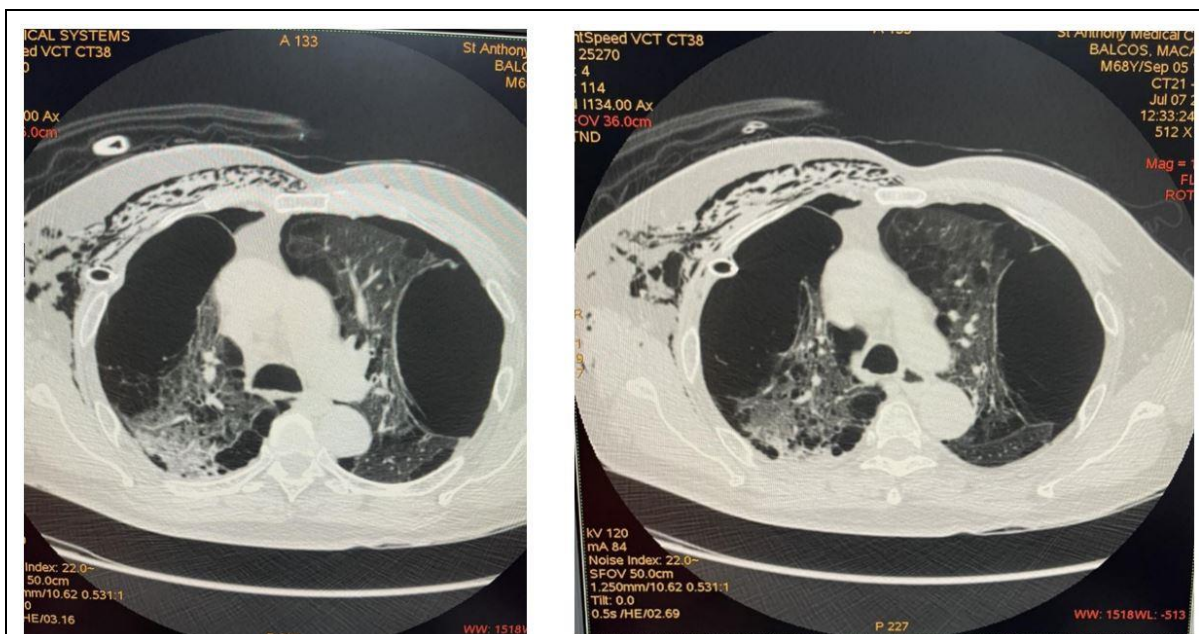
HRCT; Multiple bullae and bleb formations, both upper hemithoraces. Centrilobular and paraseptal emphysematous changes, bilateral. Minimal pneumothorax, bilateral, more pronounced on the left. Extensive subcutaneous emphysema, both anterior and right lateral chest walls as well as in the right axillary, right upper arm and right lower cervical regions. Reticular and ground-glass opacities in the right lung are likely due to an infectious/inflammatory process (e.g. pneumonia). Prominent and enlarged mediastinal lymph nodes. Atherosclerotic aorta and coronary arteries. Osteodegenerative changes of the spine. Hepatic steatosis.
